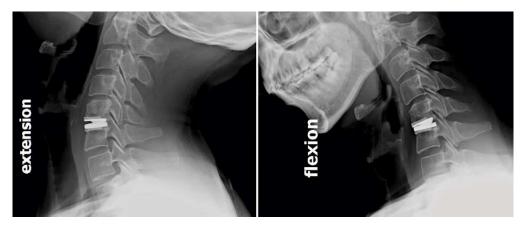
Extension and flexion radiographs showing an artificial disc with preserved segmental motion. (From https://bmcmusculoskeletdisord.biomedcentral.com/articles/10.1186/s12891-019-2509-0)
